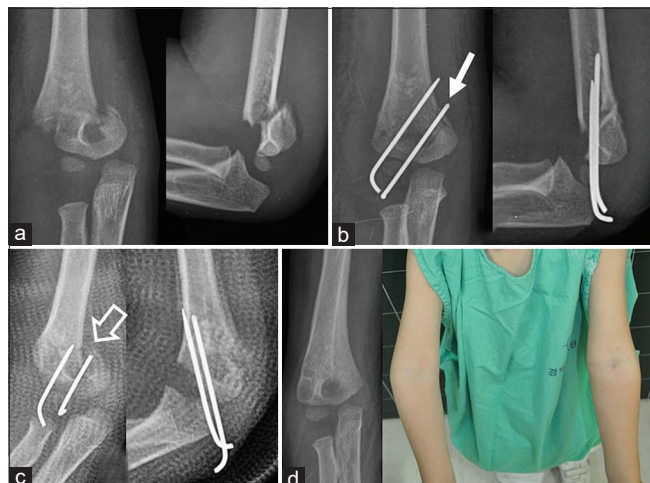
Preoperative radiographs of a 4-year-old boy with a type III supracondylar humeral fracture (a). Postoperative radiograph shows a satisfactory reduction and a sufficient pin spread after lateral-entry pinning (b). Note that the distal pin enters the fracture site (arrow). 2-week postoperative radiographs demonstrate loss of reduction (arrow, c). Eventually, the deformity of cubitus varus occurred 6 months after operation (d).
